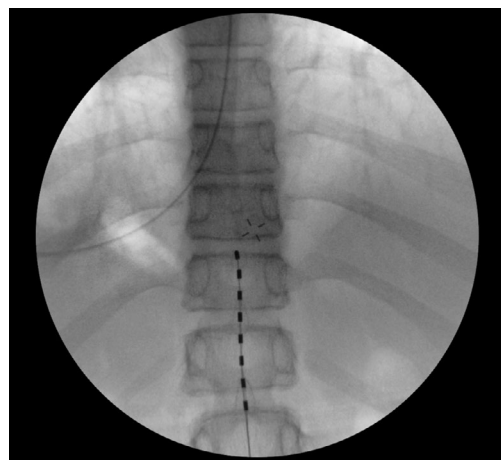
Intraoperative radiography and the position of the eight-junction epidural electrode at the Th₁₁–Th₁₂ vertebrae level
